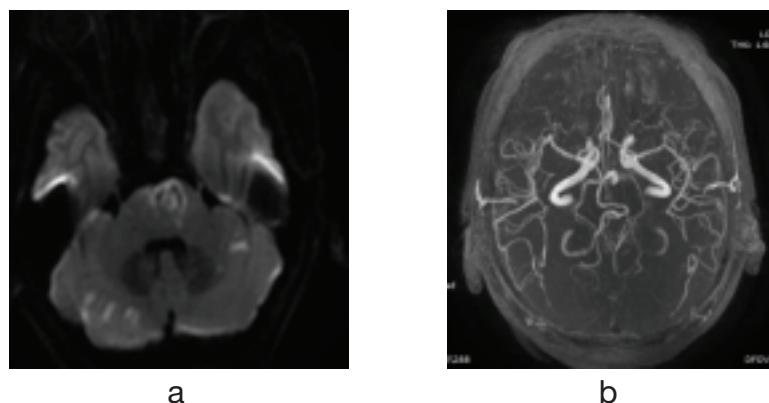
Postoperative brain DWI and MRA. (a) The brain DWI shows left pontine infarction. (b) Brain MRA shows the patency of the vertebrobasilar trunk artery.
